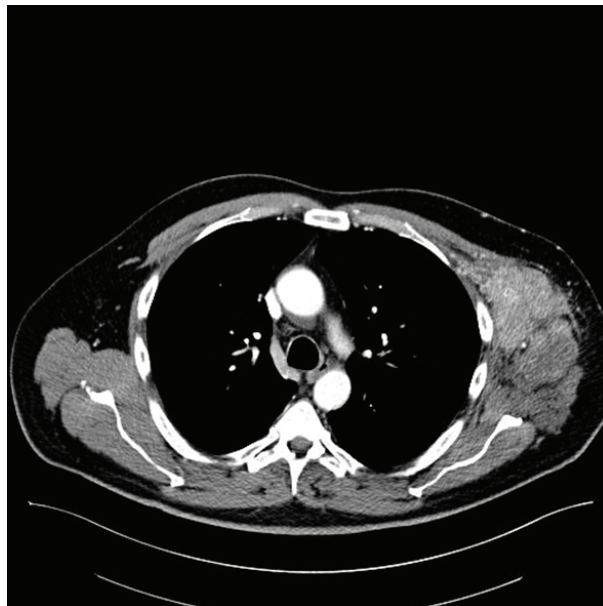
Image of computed tomography with axillary nodal masses at left.
